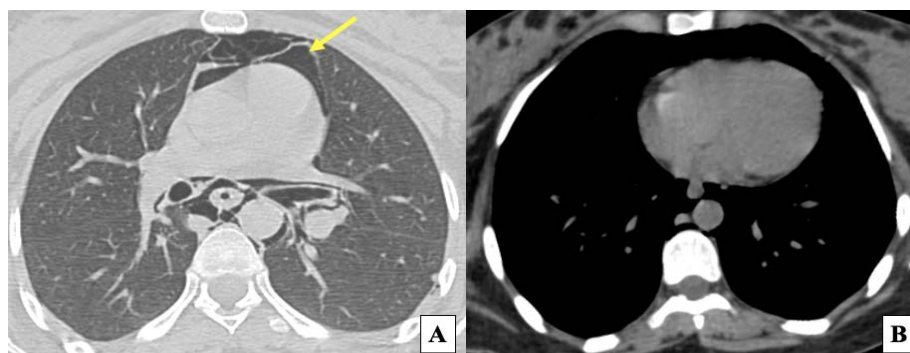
Axial Chest CT images in lung window (A) and mediastinal window (B) showing diffuse pneumomediastinum (arrow) with no pleural effusion or parenchymal abnormality.
